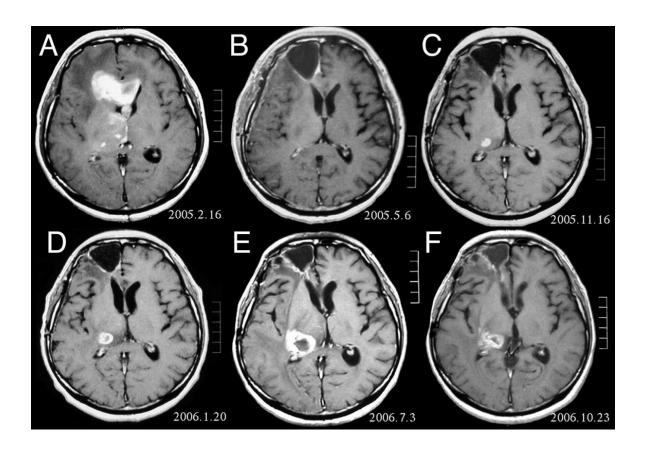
An Example Image of a MRI Scan of the Brain (Siegfried 2014)
